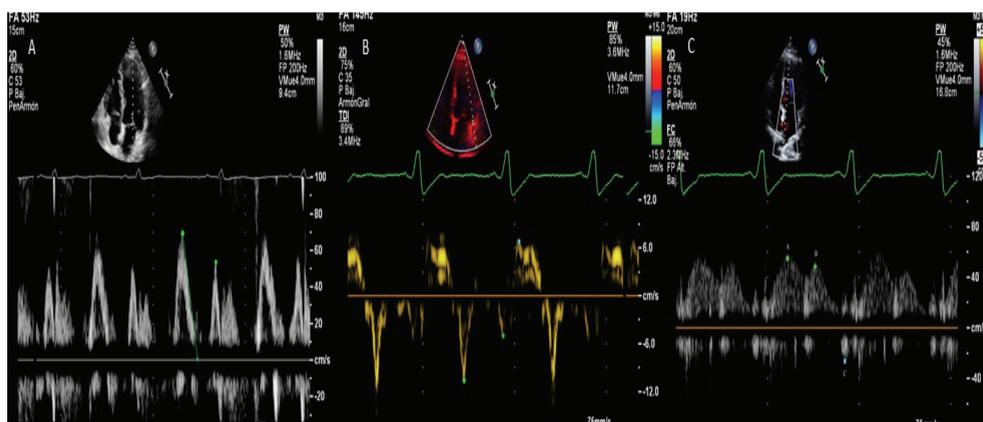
Normal diastolic Doppler patterns: A) Mitral inflow. B) Mitral annular tissue Doppler. C) Pulmonary venous flow
